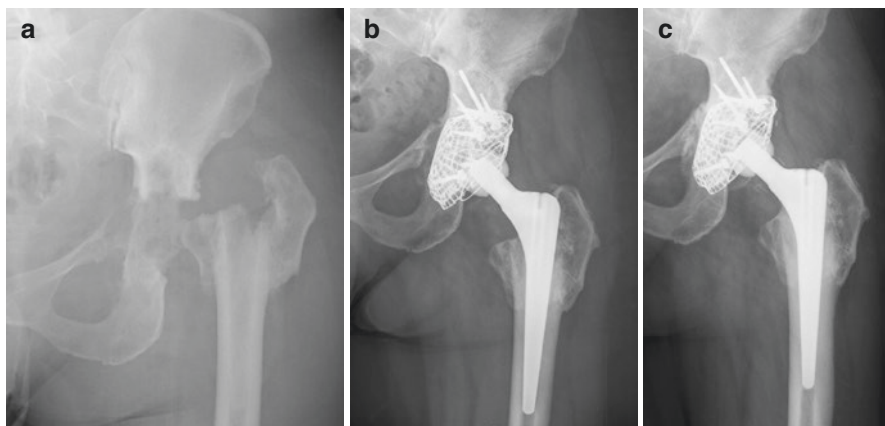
(a) Preoperative radiograph of the hip after removal of a metal-metal total hip arthroplasty that developed a pseudotumor and a bone defect at the acetabular medial wall. (b) Postoperative radiograph shows impacting bone grafting in the acetabulum and a cementless femoral stem than were used in revision surgery. (c) The bone defect is remodeled at 7 years. The clinical result is excellent
